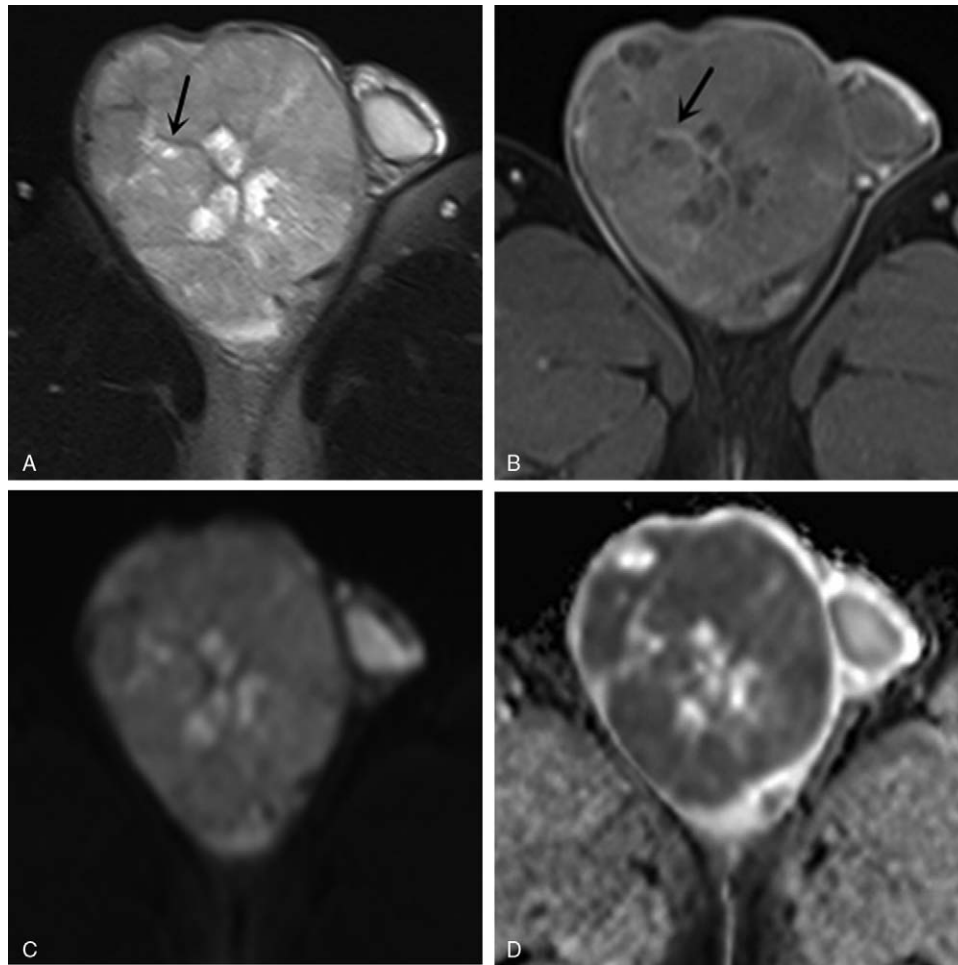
Images of a 47-year-old man with seminoma in right testis. (A) Axial fat-suppressed T2-weighted image shows a hypointense multinodular tumor with focal necrosis and hypointense septa (arrow). (B) Axial arterial phase fat-saturated gadolinium-enhanced T1-weighted image displays that the fibrous septa is more enhanced than the remaining tumor tissue (arrow). (C) Axial diffusion-weighted imaging (DWI) reveals a hyperintense mass with a mean apparent diffusion coefficient (ADC) value of $0.71 \times 10^{-3} \text{ mm}^2/\text{s}$ (D).
